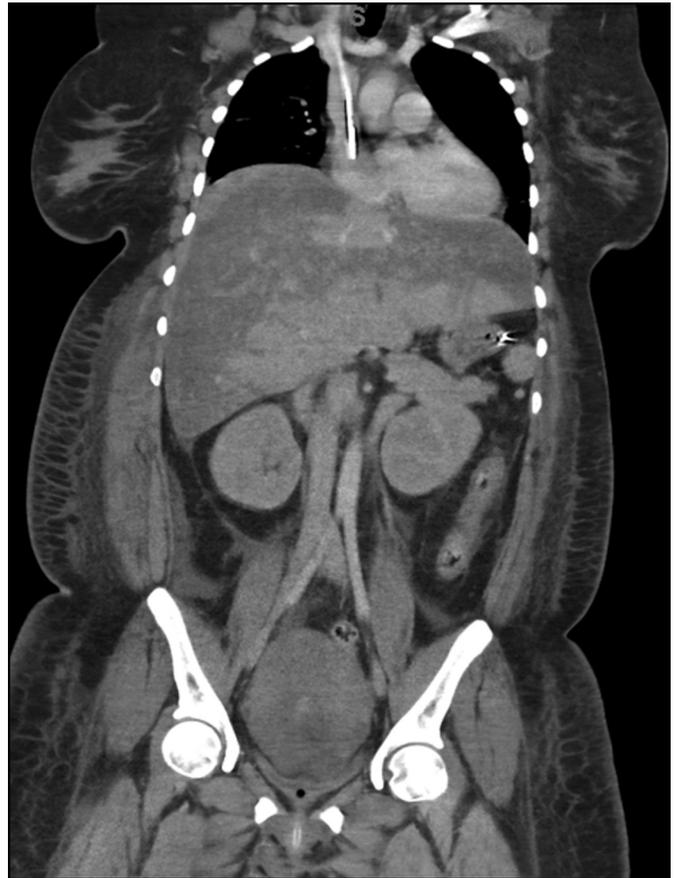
Coronal view of the patient's liver on a CT scan, demonstrating marked peripheral hypoattenuation with central sparing consistent with massive hepatic infarction.
